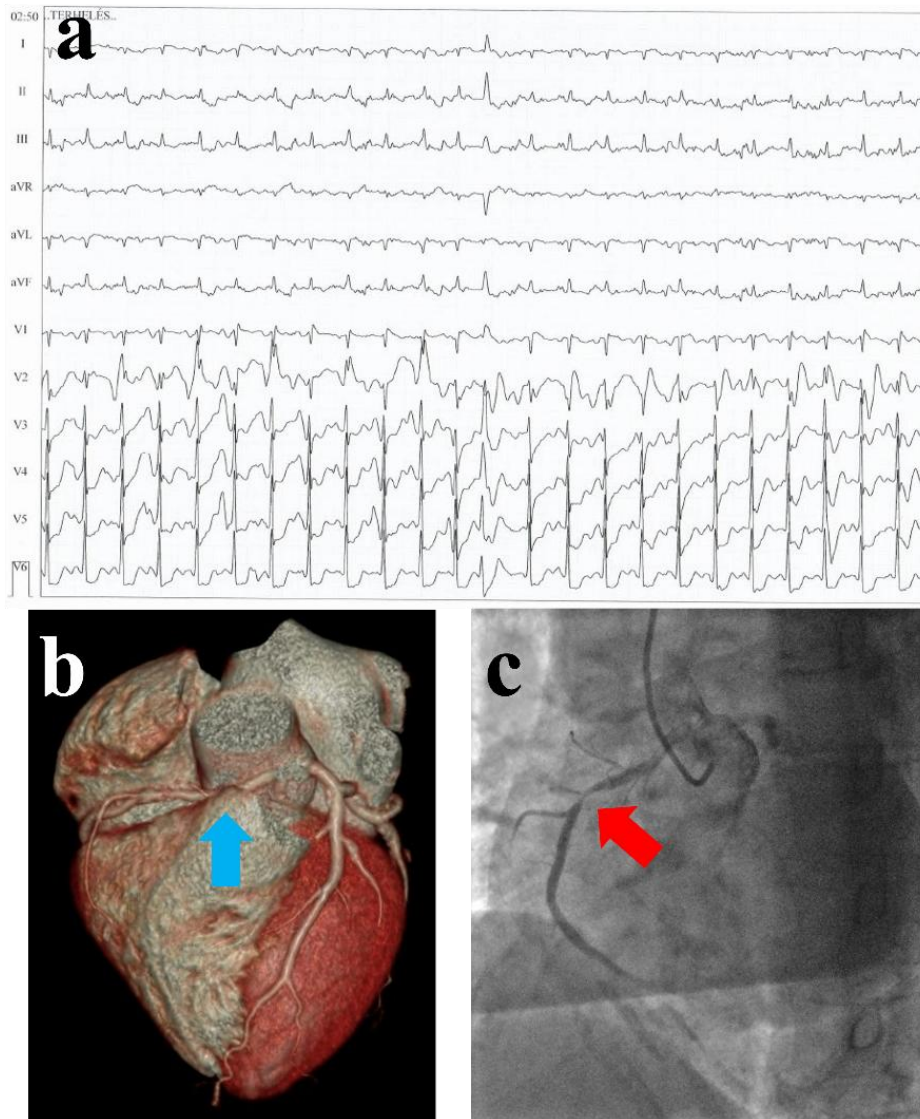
The case of a 60-year-old female amateur runner, with non-COVID-19-related findings. (97) She had treated hypertension, the SARS-CoV-2 caused mild symptoms, and she still suffered from weakness 3 months after the infection. During her second visit, he CPET examination revealed significant horizontal 2 mm ST-depression in V4-V6 (panel A). The patient was referred to cardiac CT, where anomalous origin of the right coronary artery with a significant atherosclerosis was revealed (panel B). Due to these findings, a percutaneous coronary intervention was recommended, and a drug-eluting stent implantation was carried out (panel C). A dobutamine stress echocardiography was also performed after the intervention, where no ischemic regions, or wall motion abnormality were detected. The asymptomatic patient was advised to perform light-to-moderate intensity sport activities.
